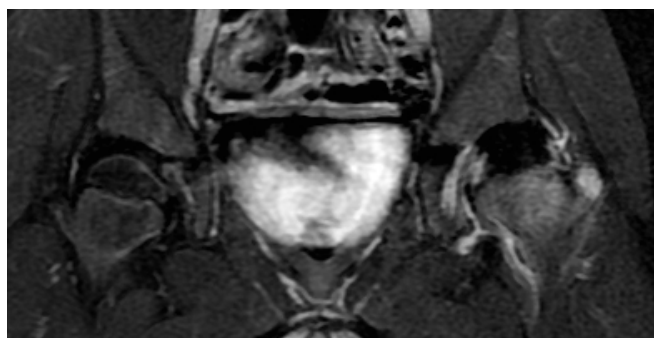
Perfusion MRI scan of a child with Legg-Calvé-Perthes disease of the left hip. Close to 80% of the epiphysis is avascular.
